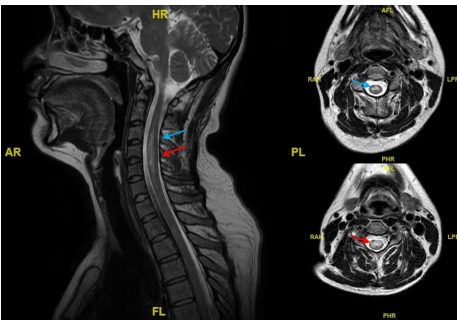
Sagittal (a) and axial (b, c) cervical spinal T2 weighted Magnetic Resonance Imaging (MRI) shows C3-C6 spinal cord infarction (blue arrow: C3 cord level, red arrow: C4 cord level).
